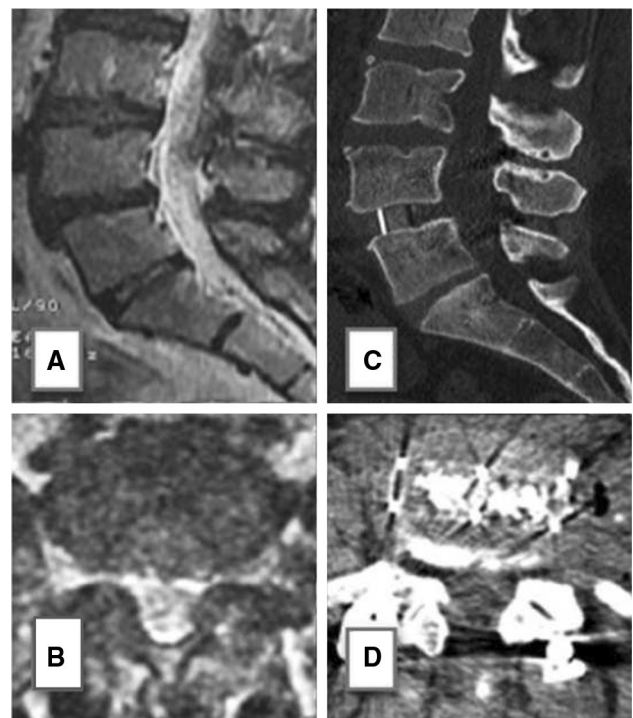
a, b T2-weighted MRI scans revealed DDD at L4–L5, without signs of instability. c, d Postoperative CT scan at 2 years follow-up showing the interbody fusion obtained by LLIF cage and completed by a posterior percutaneous pedicular screws insertion
